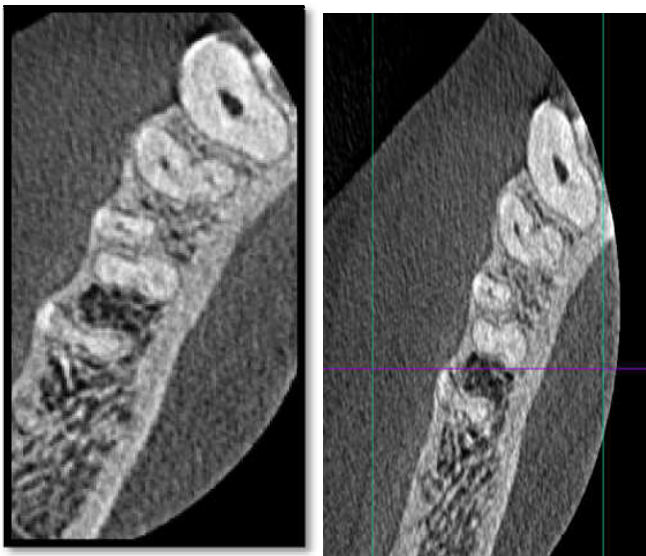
The axial plane of CBCT of #45 showing three canals. (Apical & middle Section)
